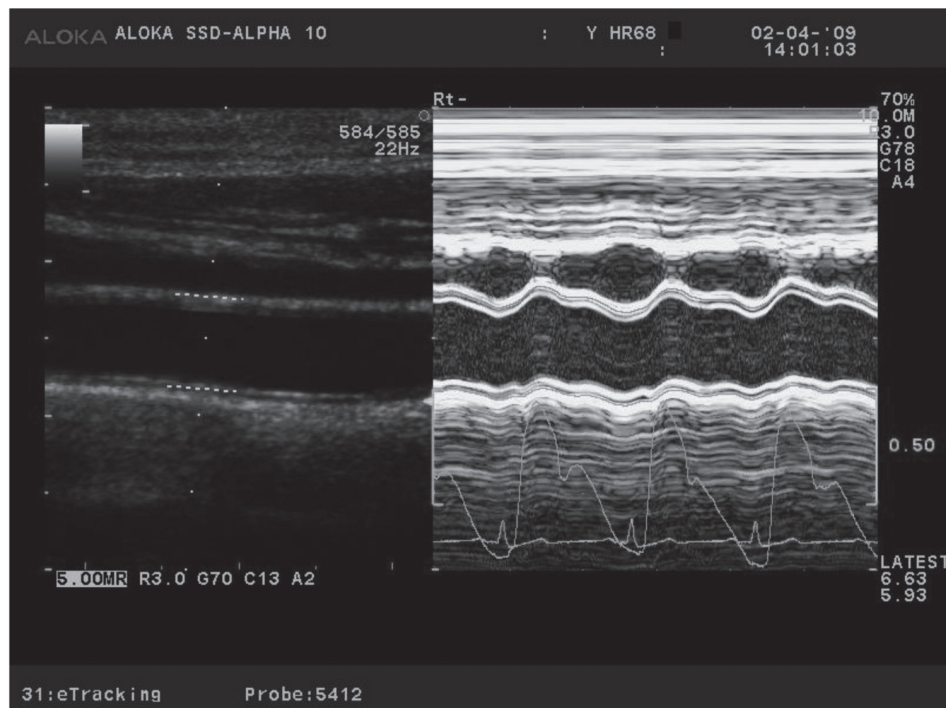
Ultrasound and echo-tracking of common carotid artery
